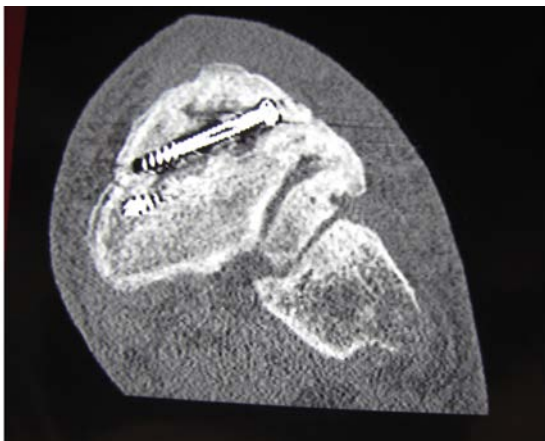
CT navicular, Case 1.
